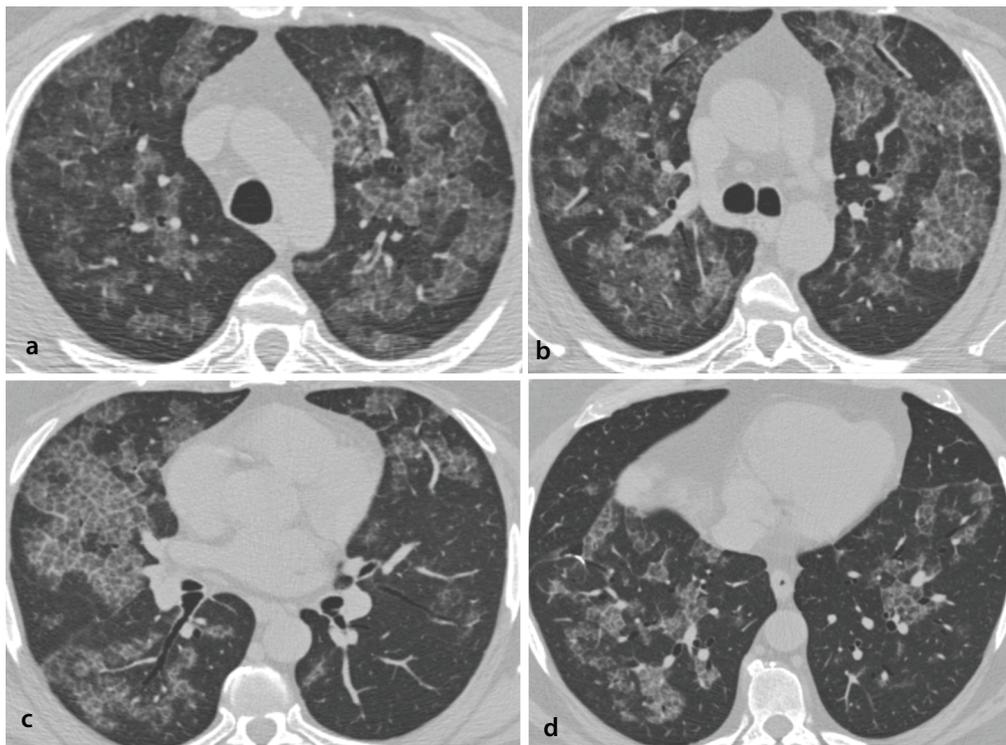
Pulmonary alveolar proteinosis pattern on chest computed tomography (CT). Axial CT images (a–d) demonstrate the characteristic “crazy-paving” pattern, consisting of diffuse or patchy ground-glass opacities superimposed with smooth interlobular septal thickening and intralobular lines. The distribution is bilateral and symmetric.
